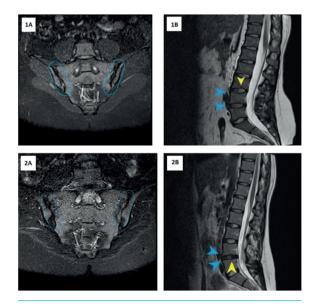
1A) Magnetic resonance imaging (MRI) findings in patient A. Grade 3 sacroiliitis: the contours of the articular surfaces are uneven, and jagged due to subchondral sclerosis and erosions in STIR sequence; 1B) MRI findings in patient A. Degenerative changes of the spine: sharpening of the thoracic and lumbar vertebrae by small osteophytes (blue arrows), sclerosis of the end plates of the vertebral bodies (yellow arrow) in T1 sequence; 2A) MRI findings in patient B. Grade 2 sacroiliitis: subchondral sclerosis of the ileosacral joints on both sides in STIR sequence; 2B) MRI findings in patient B. Lower thoracic and lumbar vertebrae marginal sharpening by small osteophytes (blue arrows), sclerosis of the end plates of the vertebral bodies (yellow arrow) in T1 sequence.
